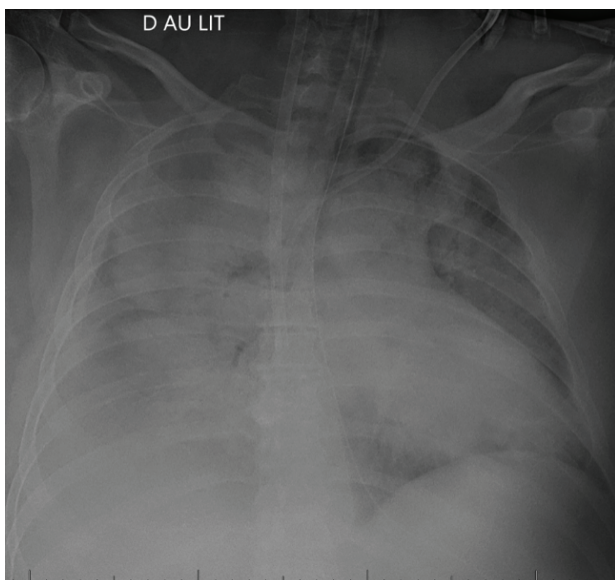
Initial Chest X-ray with bilateral pulmonary infiltrates.
